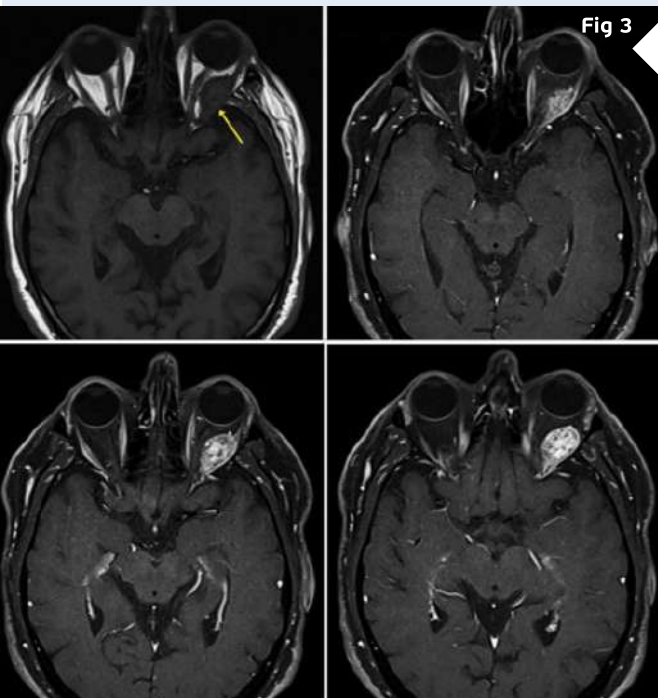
Axial MRI of the orbits with contrast-enhanced images (left top & bottom) showing the high signal intensity pattern of the fusiform mass. Though initially the tumor seems to be encapsulated (top right & left), lower cuts reveal the intimate imbrication with the muscular tissue (bottom right & left).
